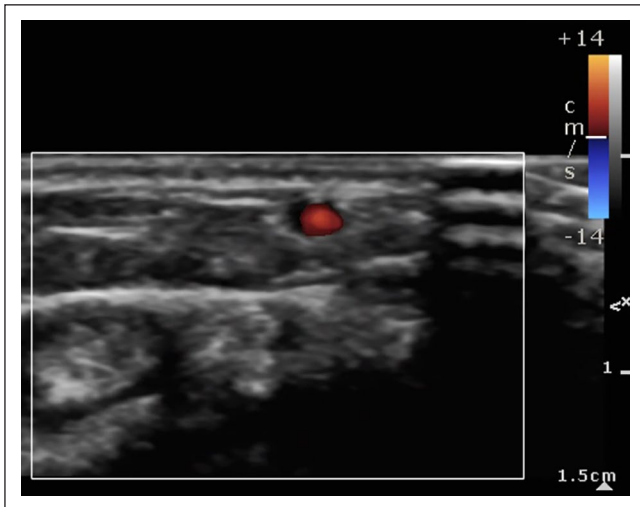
Cephalic vein with color flow Doppler imaging during saline infusion evidencing flow.
